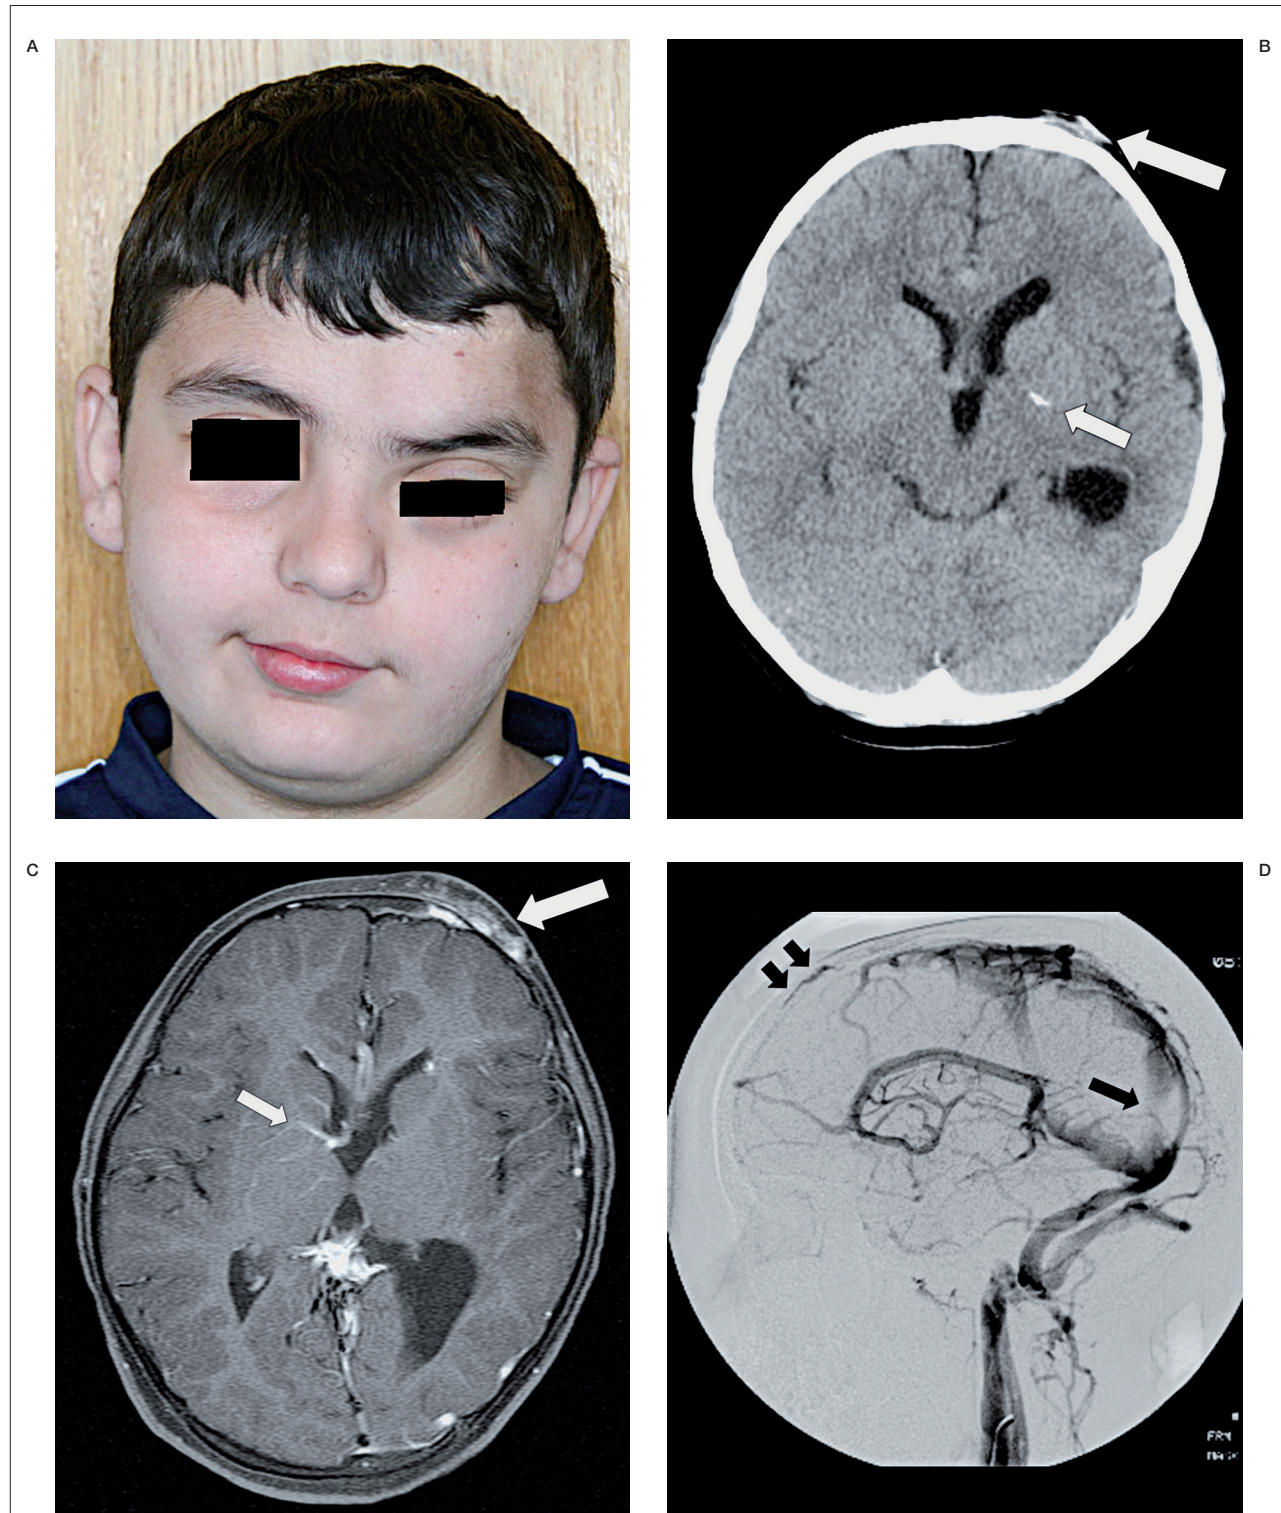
A) First Patient. There is a small left orbit and globe with venous expansion of the left forehead. B) Non-contrast enhanced head CT scan reveals a focal calcification in the left basal ganglia (small arrow) and venous malformation of the scalp (large arrow). C) Enhanced Axial T1-weighted MR Image shows smaller left cerebral hemisphere with DVAs in the right caudate nucleus and thalamus (small arrow). The anomalous transcalvarial and epicranial veins are clearly depicted (large arrow). D) Venous phase of cerebral angiography shows global anomalies of the venous drainage of the brain. Note the presence of persistent falcine sinus (long arrow) and fenestrated, underdeveloped superior sagittal sinus with retrograde filling of the sinus pericranii (short arrows).
